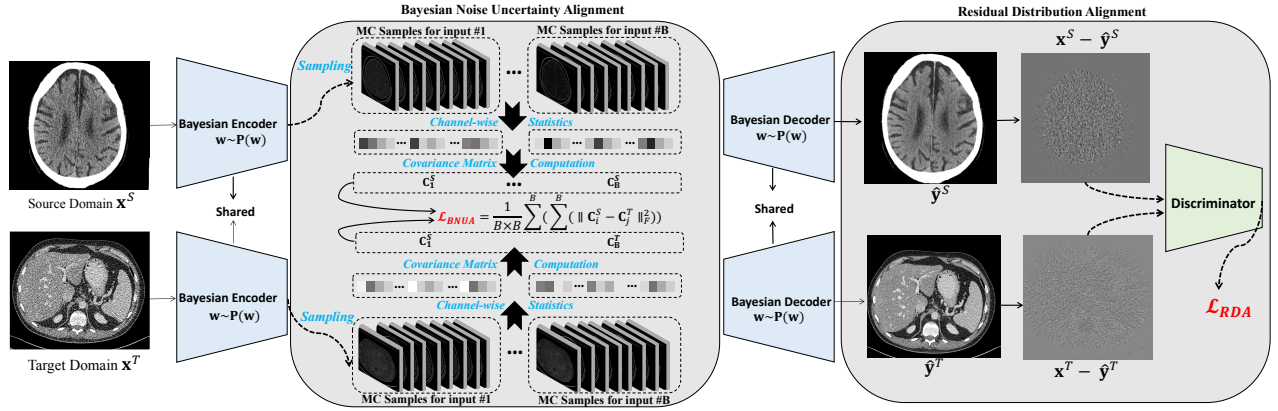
The overall framework of the proposed method. The CT reconstruction model is disentangled into a BNN-based encoder for the feature extraction and a BNN-based decoder for the content reconstruction from extracted features. By conducting MC sampling, the Bayesian noise uncertainty alignment can be imposed for the alleviation of noise distribution in the latent space. The residual distribution alignment is to align noise distribution of two domains in the image space using the residual information.
